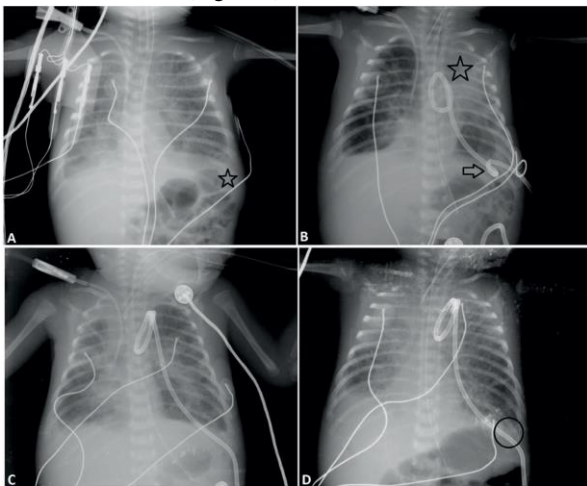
A. The left costophrenic sinus of a patient with very early preterm birth and intrauterine growth retardation who has developed non-immune hydrops is occluded (black star). A decision is made to insert a percutaneous drainage catheter in the patient, who was found to have a 4 cm effusion on the USG. B. While the transudate fluid continues to flow, the drainage is abruptly interrupted nine days after catheter insertion. On the chest X-ray, it is noticeable that the ventilation of the left lung is decreased and there is a significant effusion around the entire lung, which is more pronounced in the apical region (black star). This is due to the fact that the catheter has been twisted and occluded at the point of entry into the skin (black arrow) and therefore the more distal portion of the catheter is surrounded by a fibrin sheath. C. At a second session on the same day, a drainage catheter is again inserted from the left side. On the chest X-ray taken 2 hours later, it can be seen that the ventilation of the left lung has improved significantly and the amount of fluid has significantly decreased. D. Drainage gradually decreased and stopped seven days after insertion of the second catheter. The patient's chest X-ray shows that the ventilation of the left lung has wholly normalized, and there is no more effusion. Although the costophrenic sinus is closed on the right
